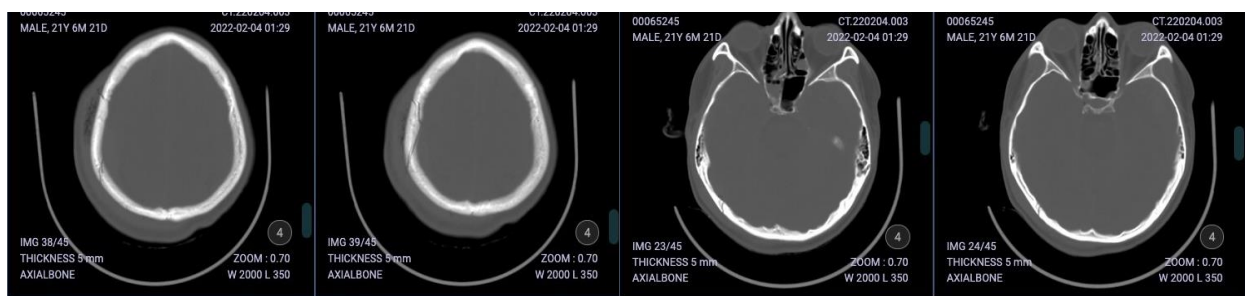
CT Scan Bone Window; CT scan bone window shows fracture of the os calvaria in the right parietal and right occipital region
